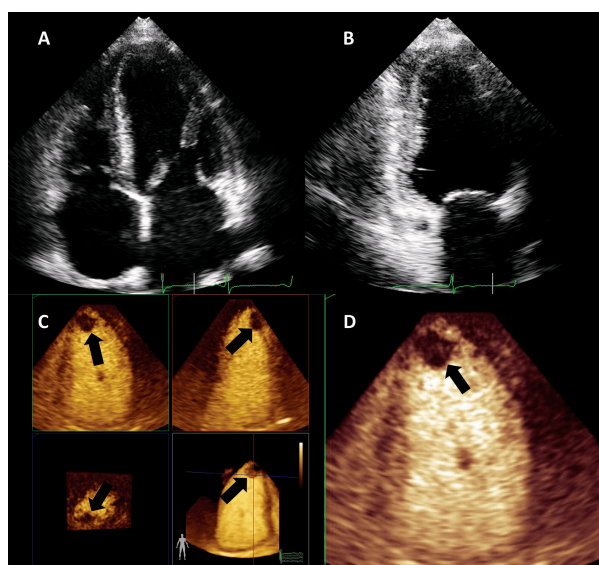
Detection of an apical thrombus in a patient with severely depressed EF. Native images in apical 4 (A) and 2 chambers (B) do not demonstrate the presence of an apical mass. (C) 3D contrast-enhanced echocardiography demonstrating an apical filling defect (thrombus-arrows). (D) Apical 2-chambers 2D contrast-enhanced image, the thrombus is present in the apical LV. Images modified with permission from Strachinaru *et al.* [79].
